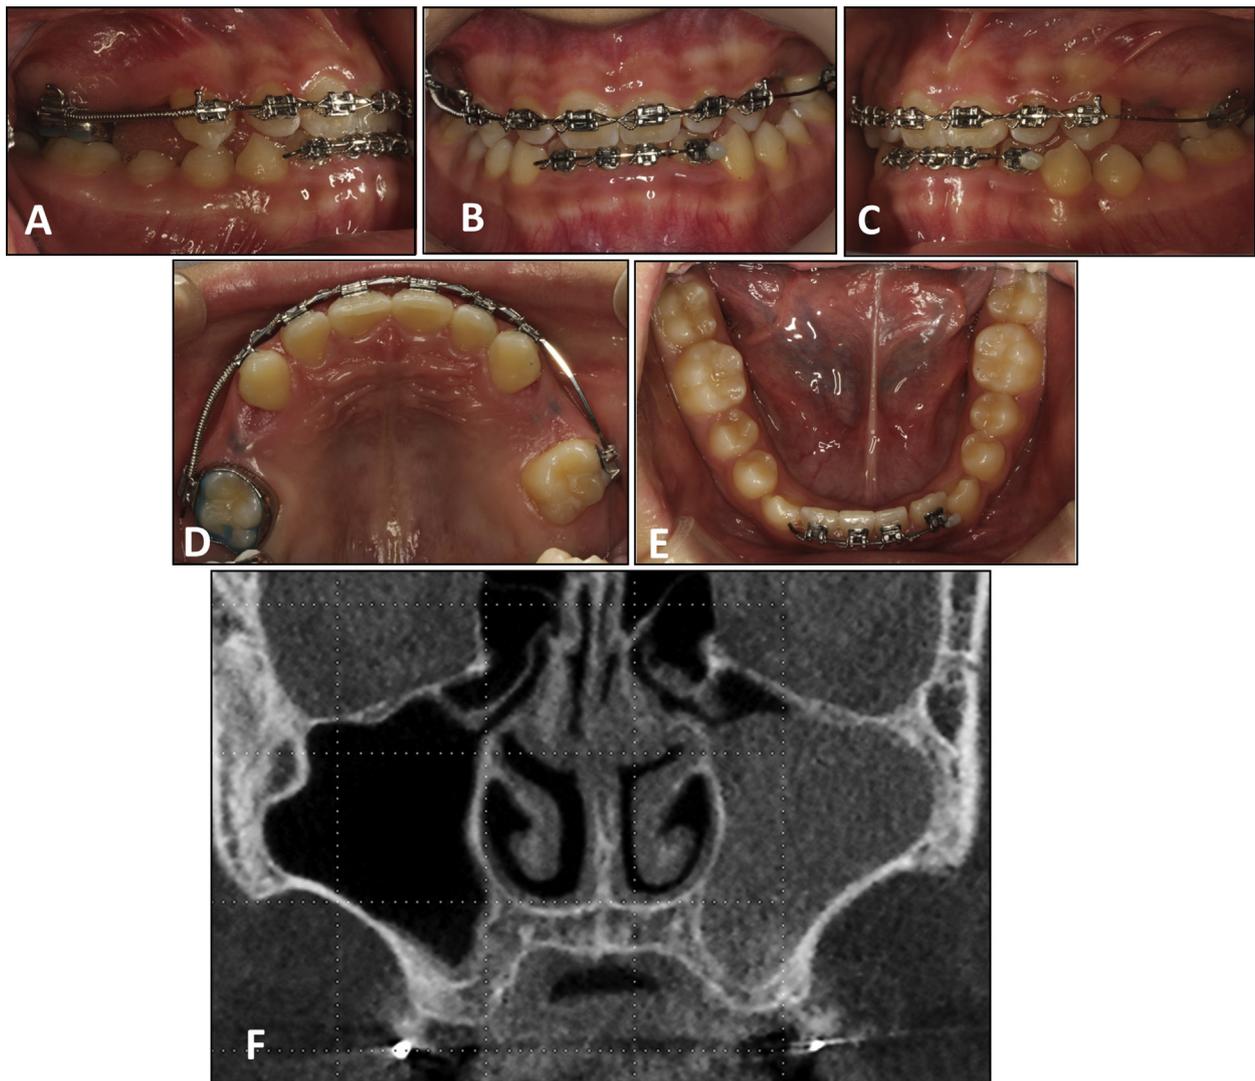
A-E, Intraoral view 1 month before right-side transplantation. F, Coronal section of the CBCT scan through the sinusal complex. There was greater mucociliary activity at the left maxillary and ethmoidal sinuses. Sinusitis was diagnosed from the radiographic findings and clinical examinations at left side (11 years 10 months of age).
